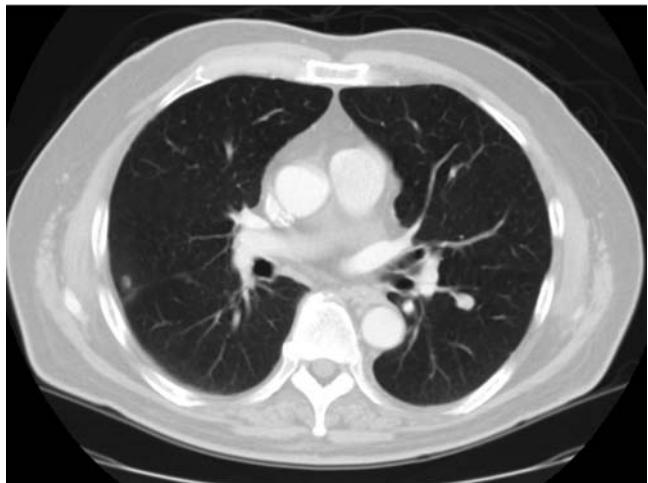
CT of chest. Note small round nodule in the left lower lobe, below the carina. Also an area of opacity in the minor fissure of the right lung, biopsy demonstrated adenocarcinoma, clear cell variant.
